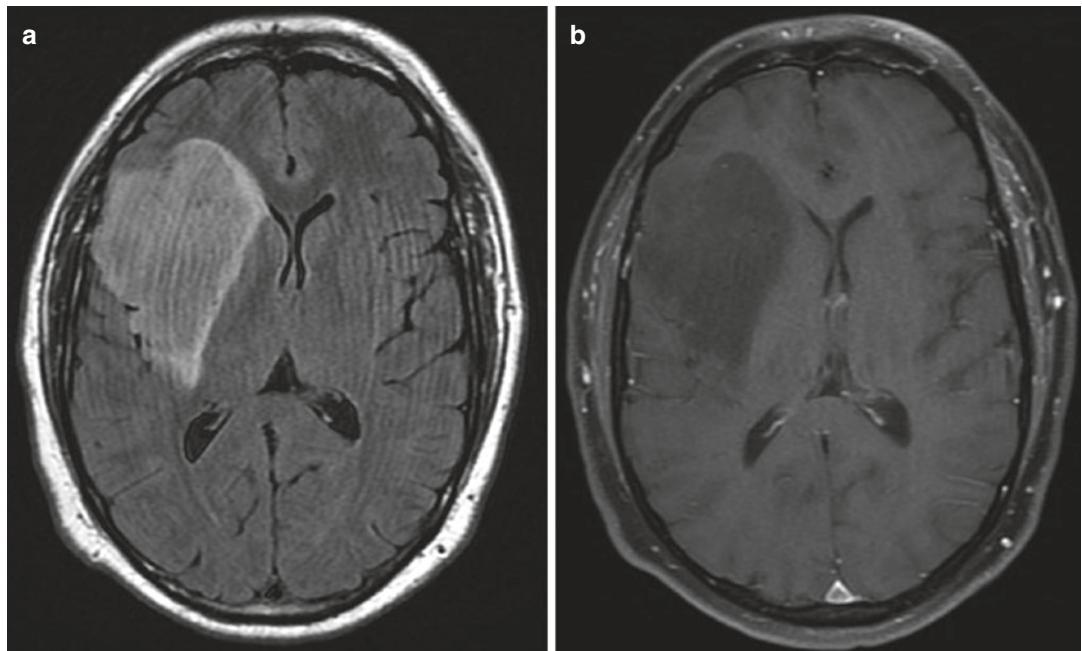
(a) T2 flair and (b) post-contrast T1 axial MR images showing an example of a right insular, low-grade astrocytoma, also known as a glioma
